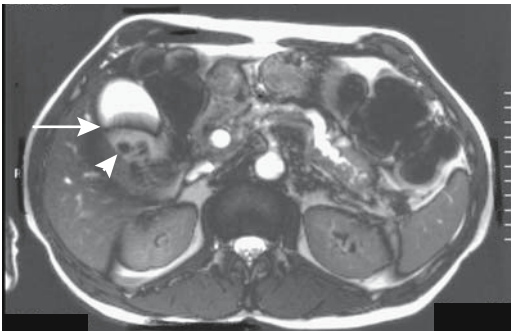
T2-weighted image of adenomyomatosis. The gallbladder contains a transverse fold (arrow) and several gallstones (arrowhead). The pancreatic and bile ducts are dilated secondary to a pancreatic cancer. (Source: Burgener FA, Meyers SP, Tan RK, Zaunbauer W. *Differential Diagnosis in Magnetic Resonance Imaging*. Stuttgart: Thieme, 2002, with permission.)
